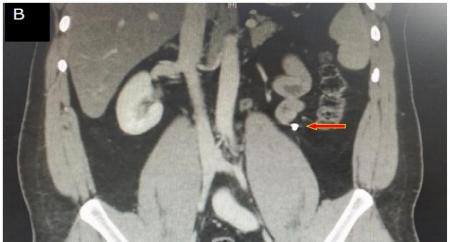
CT of the abdomen showing Shrapnel (red arrow) in close proximity to bowel loops. A: axial view, B: coronal view. Treated conservatively.
